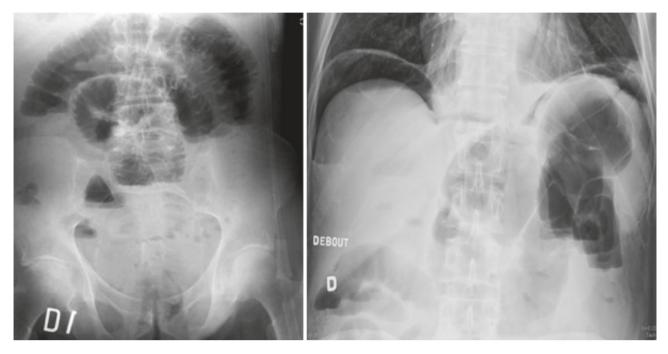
Plain X-rays (flat plates) of the abdomen: Left: distension of small intestinal loops occluded by a scar adhesion. Right: free air under the diaphragm due to a perforated duodenal ulcer
